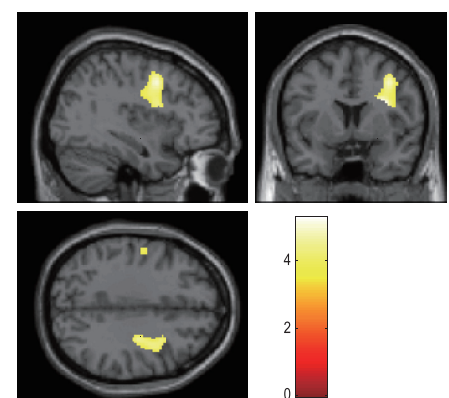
SDS fatigue item and SPECT
